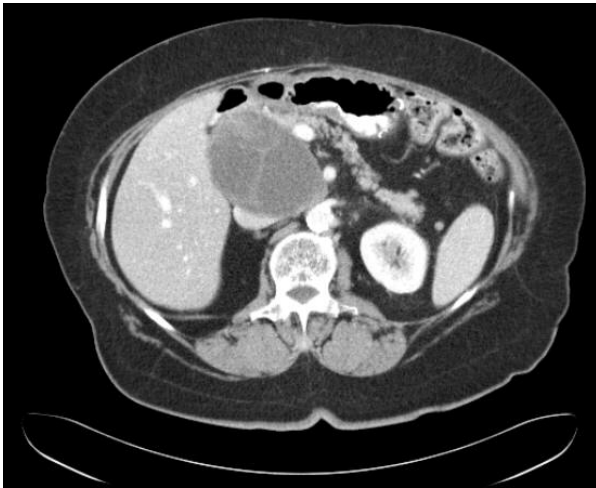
Contrast enhanced CT of the abdomen revealing a 7.3x9.4 cm septated mass in the area of the head of the pancreas with distortion of the normal anatomy.
